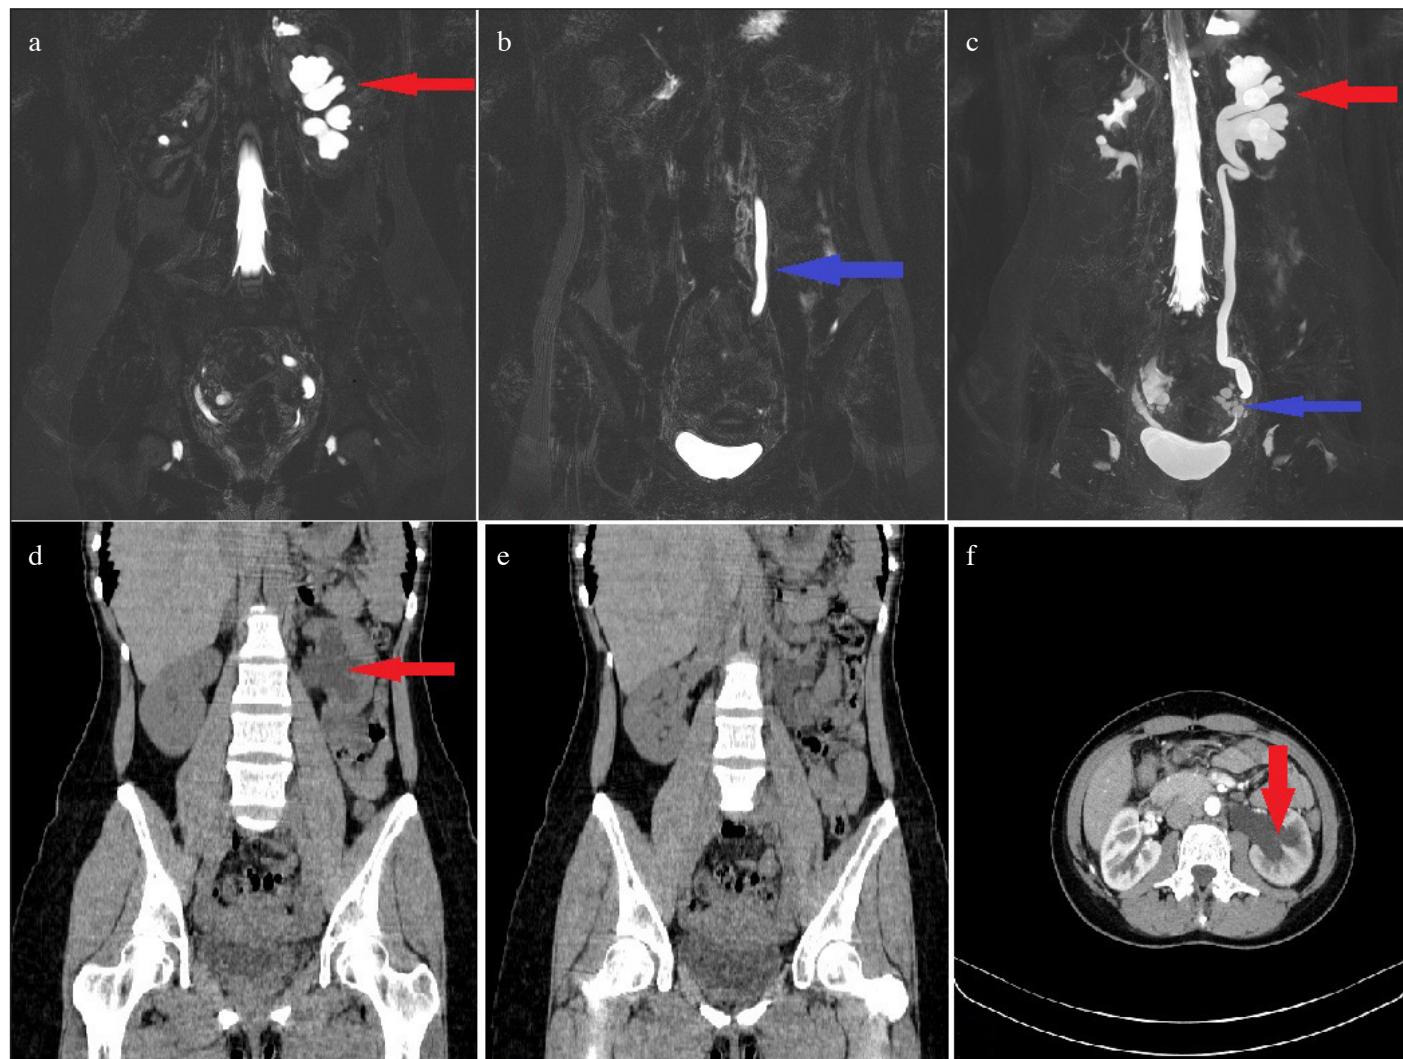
a-f. Preoperative MRI and CT images of the patient. Images a, b and c show dilated pelvicalyceal system (shown with red arrows), ureter and its stenotic segment (shown with blue arrows). Non-contrast CT images of the left dilated urinary tract are shown in images d, e and f
